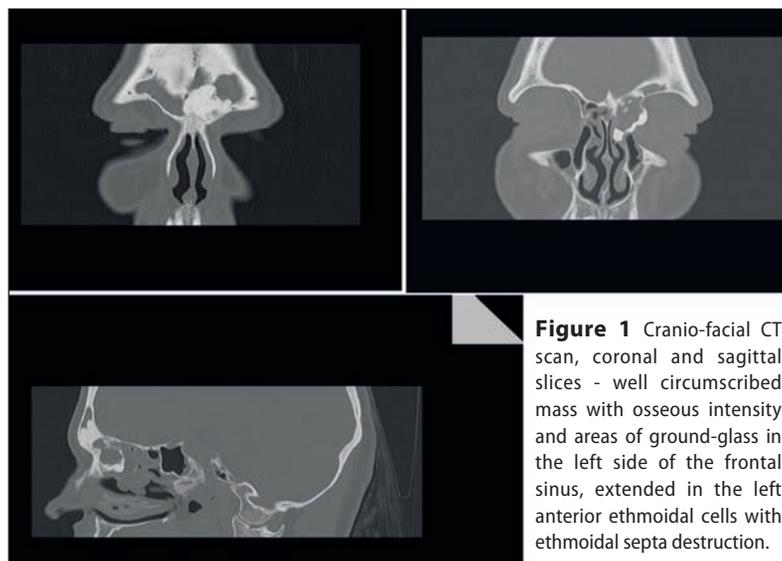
Cranio-facial CT scan, coronal and sagittal slices - well circumscribed mass with osseous intensity and areas of ground-glass in the left side of the frontal sinus, extended in the left anterior ethmoidal cells with ethmoidal septa destruction.
